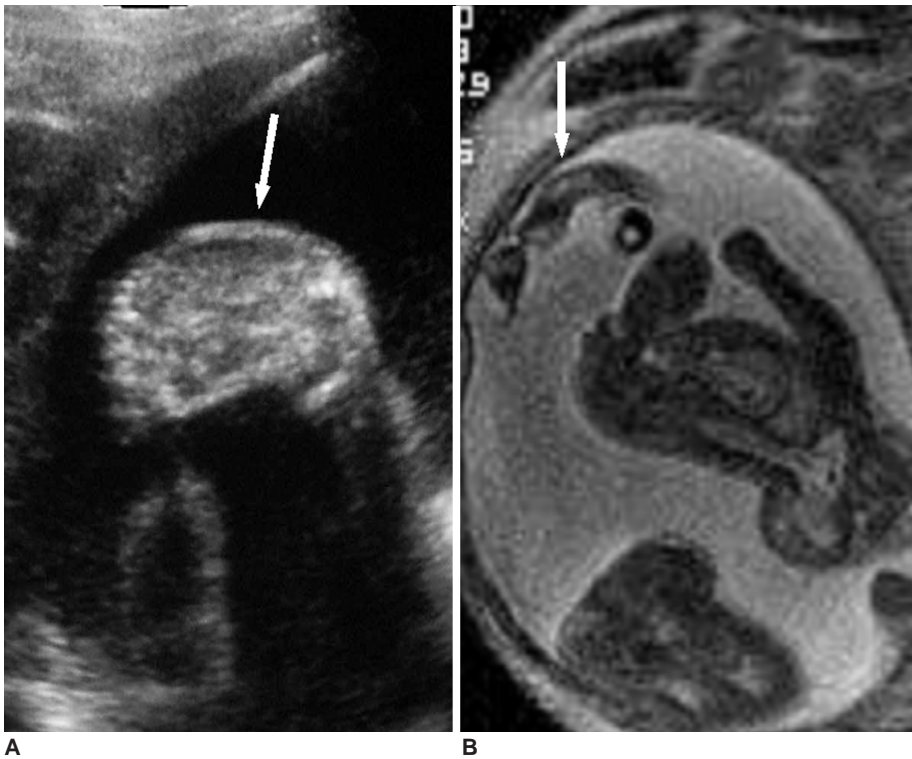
Club foot is visualized on US (A) and MR imaging (B) (white arrows).
